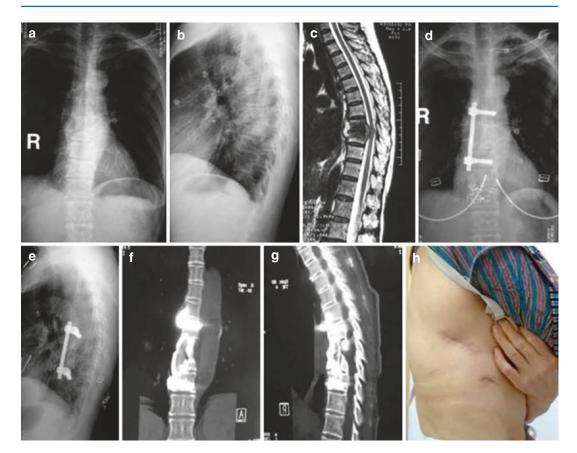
A 53-year-old female with T8–T9 TB underwent thoracoscopic-assisted anterior debridement, iliac bone autograft, and fixation with single-rod Ventrofix system (Synthes Spine, Switzerland). (a, b) AP X-ray shows paraspinal shadow, and lateral plain radiograph demonstrates a narrowed disk space at T8–T9 and a kyphotic angle of 39°. (c) MRI demonstrates vertebral destruction and paravertebral and epidural abscess with compression
